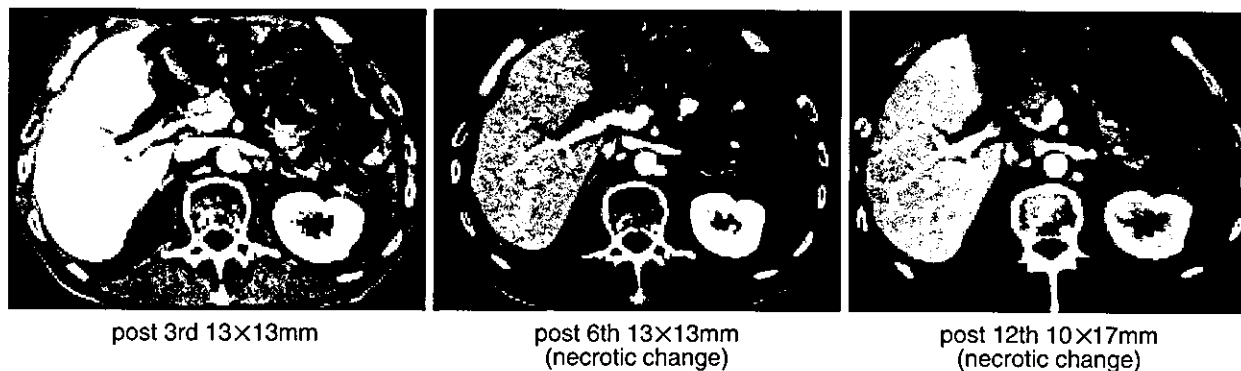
CT images of case 13.
